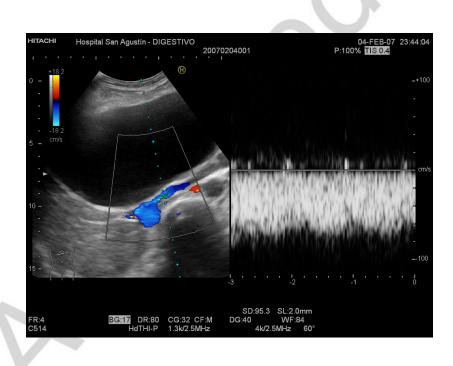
A doppler ultrasound exam confirming the presence of a SOL of 20 cm in diameter in the liver and portal vein compression with retrograde dilation and slow velocity flow.
